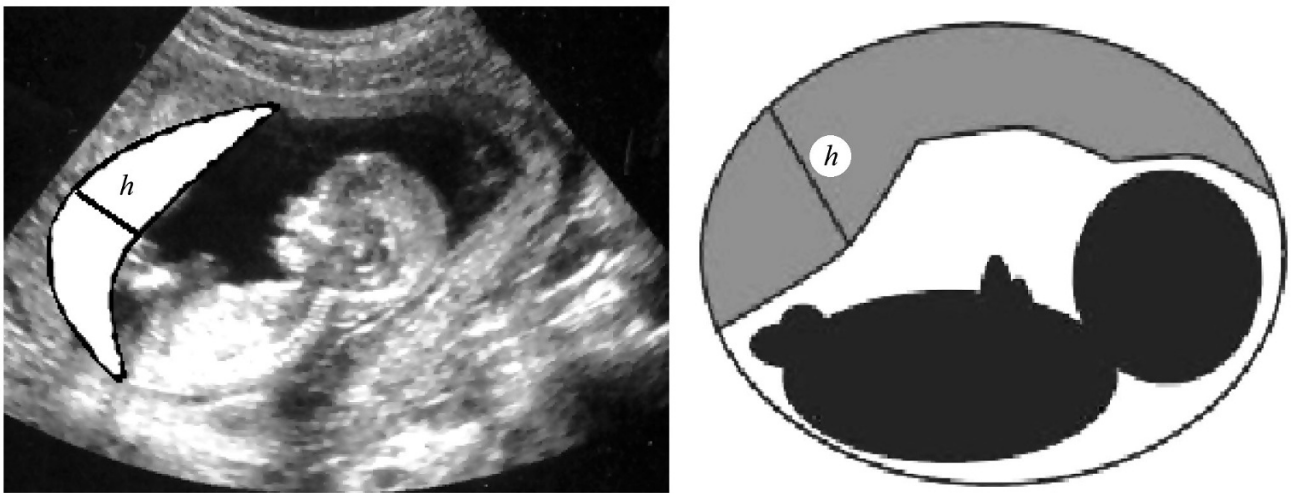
Method of determining the thickness and cross-sectional area of the placenta using a transabdominal ultrasound probe.
